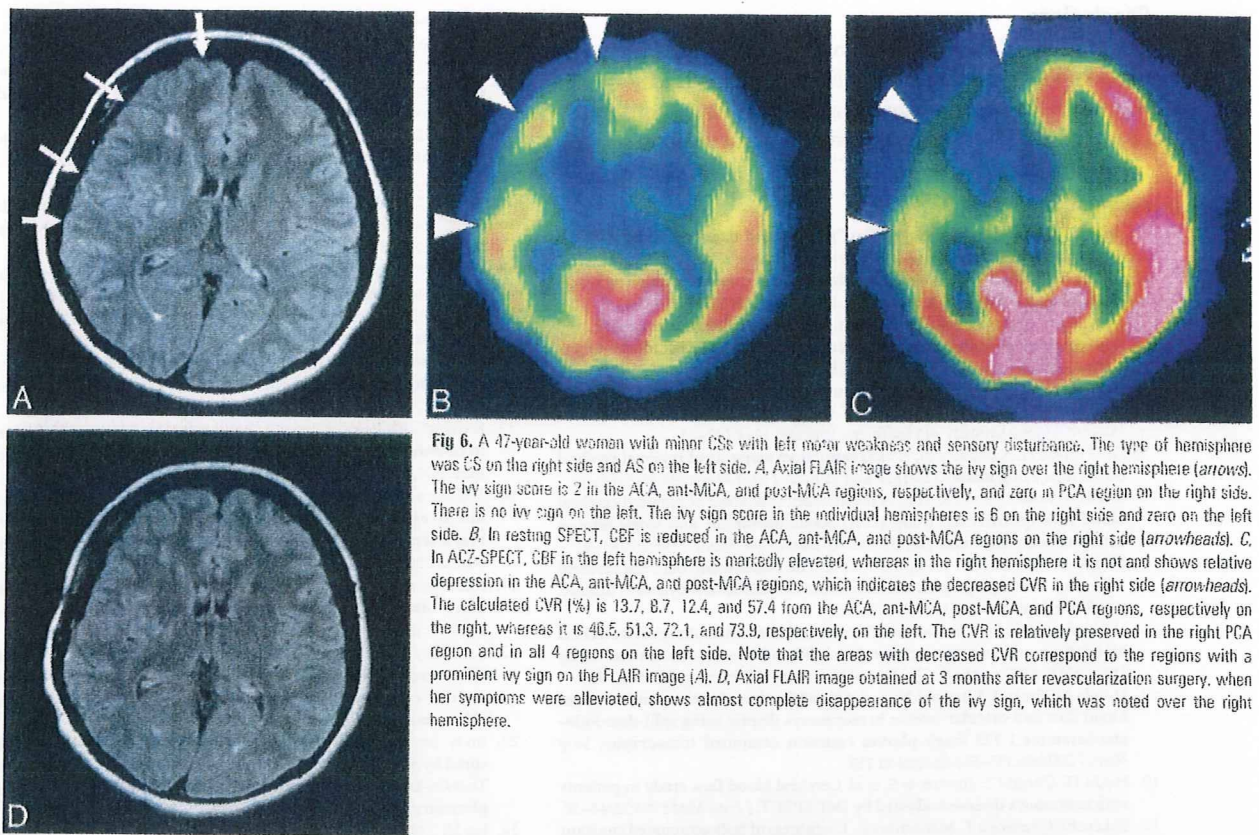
A 47-year-old woman with minor CSE with left motor weakness and sensory disturbance. The type of hemisphere was CS on the right side and AS on the left side. A. Axial FLAIR image shows the ivy sign over the right hemisphere (arrows). The ivy sign score is 2 in the ACA, ant-MCA, and post-MCA regions, respectively, and zero in PCA region on the right side. There is no ivy sign on the left. The ivy sign score in the individual hemispheres is 6 on the right side and zero on the left side. B. In resting SPECT, CBF is reduced in the ACA, ant-MCA, and post-MCA regions on the right side (arrowheads). C. In ACZ-SPECT, CBF in the left hemisphere is markedly elevated, whereas in the right hemisphere it is not and shows relative depression in the ACA, ant-MCA, and post-MCA regions, which indicates the decreased CVR in the right side (arrowheads). The calculated CVR (%) is 13.7, 8.7, 12.4, and 57.4 from the ACA, ant-MCA, post-MCA, and PCA regions, respectively on the right, whereas it is 46.5, 51.3, 72.1, and 73.9, respectively, on the left. The CVR is relatively preserved in the right PCA region and in all 4 regions on the left. Note that the areas with decreased CVR correspond to the regions with a prominent ivy sign on the FLAIR image (A). D. Axial FLAIR image obtained at 3 months after revascularization surgery, when her symptoms were alleviated, shows almost complete disappearance of the ivy sign, which was noted over the right hemisphere.
